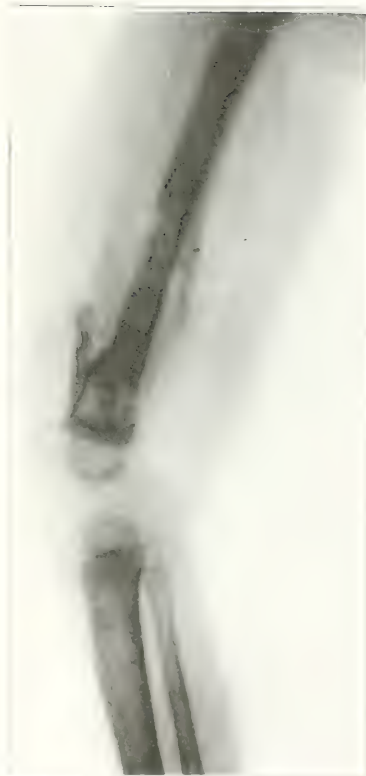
(Case 4).—Roentgenogram taken July 7, 1941, showing no sinus, no limitation of motion, no interference and considerable subperiosteal bone proliferation.
